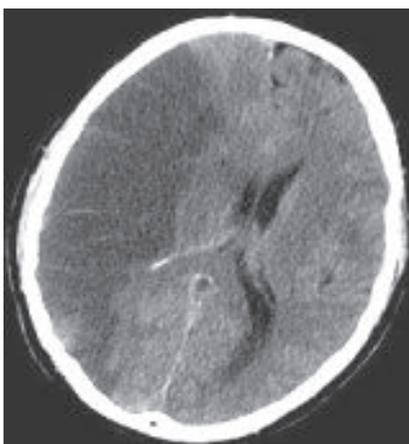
CT scan slice of the brain showing a right hemispheric stroke (left side of image)
